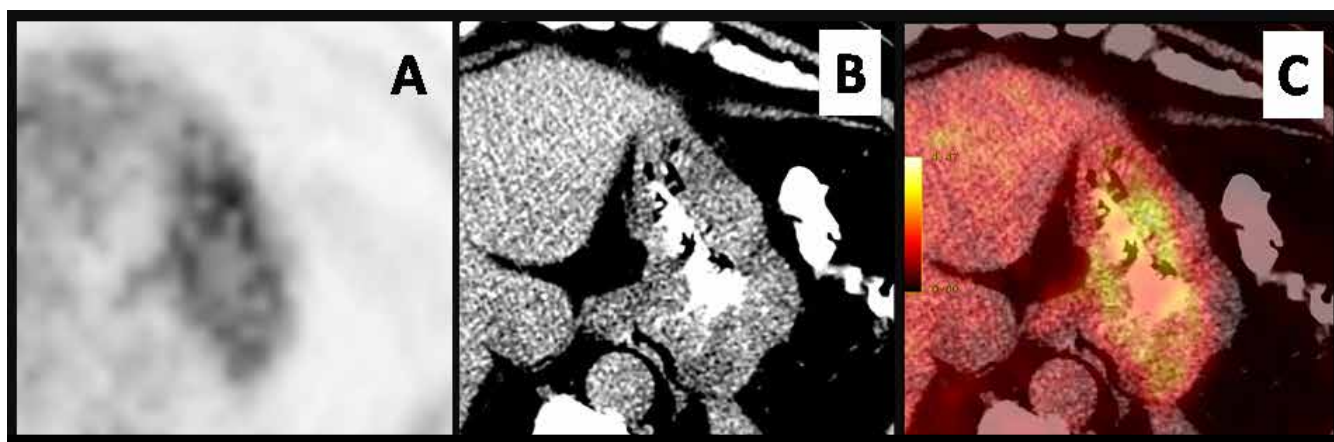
PET (A), CT (B), and PET/CT Fusion (C)
